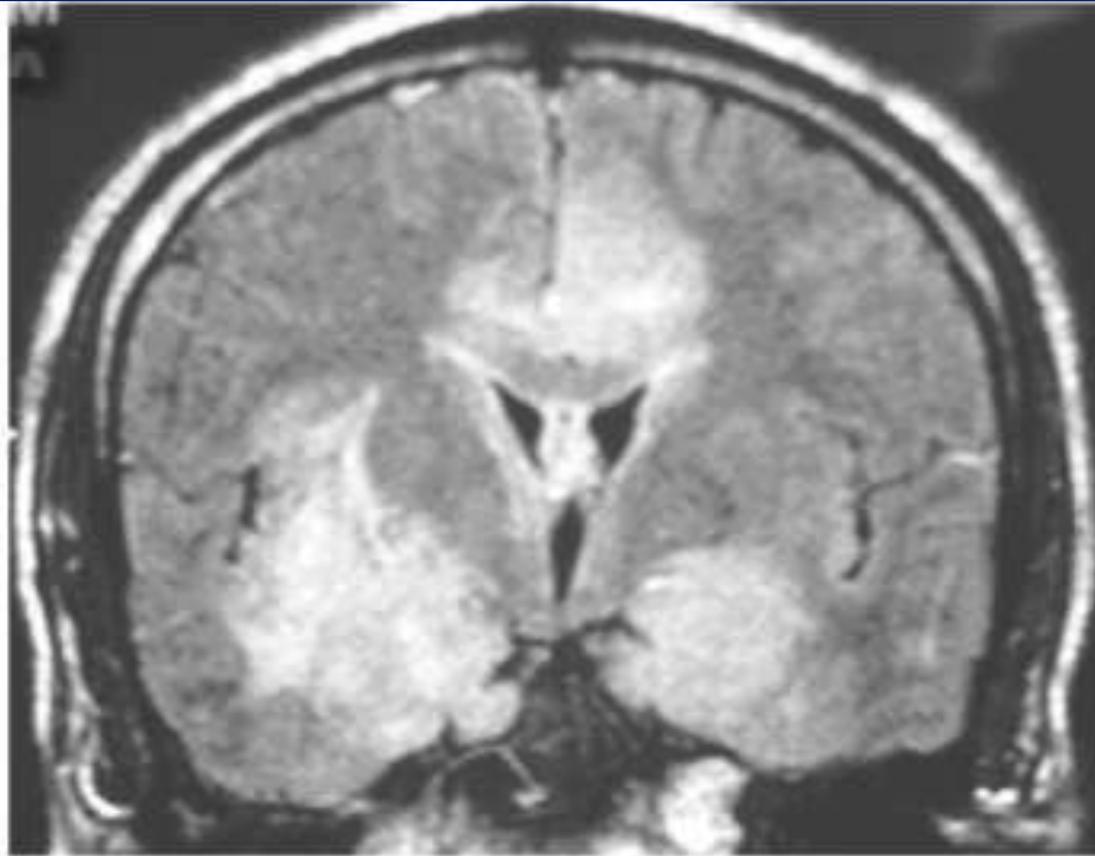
Flair MR imaging showing hyperintense lesions in both medial temporal lobes and cingulate gyrus compatible with limbic encephalitis.
